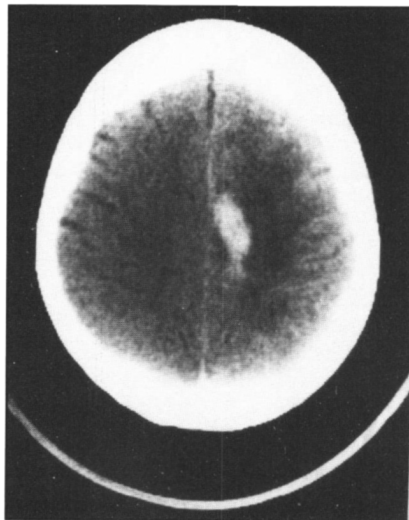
This cranial CT scan reveals the second hemorrhage, involving the area adjacent to the inter-hemispheric fissure on the left side.
